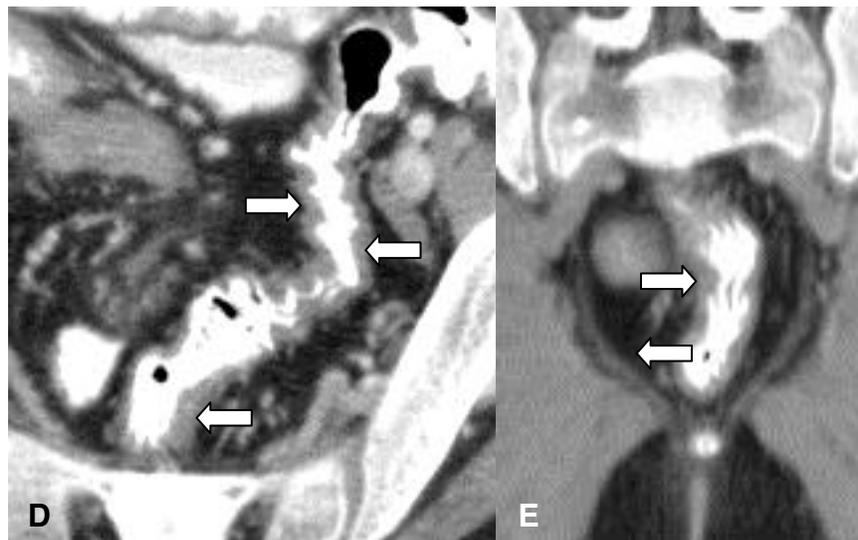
Small intestinal series shows irregular mucosal outline (*arrowheads*), separation of loops (*encircled*) and CT scan demonstrating mural thickening (*arrows*) in various segments of the intestinal tract of a 13-year old. (A-C) ileum, (D-E) rectosigmoid colon and (F-H) descending duodenum
